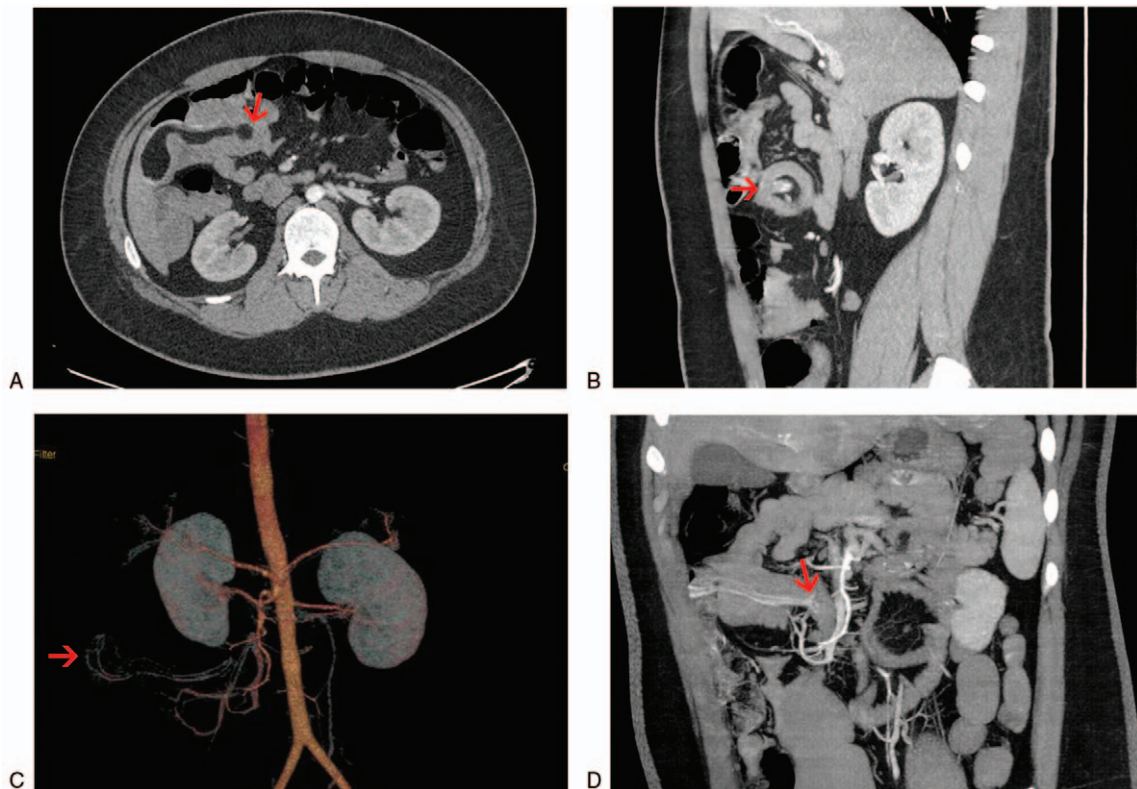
Abdominal CTA showing (A) the tortuous intestine and its mesentery in the right upper abdomen with a ring-shaped appearance (arrow) of the end of the mesentery; (B) the target sign of the intestinal canal (arrow); (C) the tortuous mesenteric vessels after vascular reconstruction; and (D) the suspicious bleeding point (arrow). CTA=computed tomography angiography.
